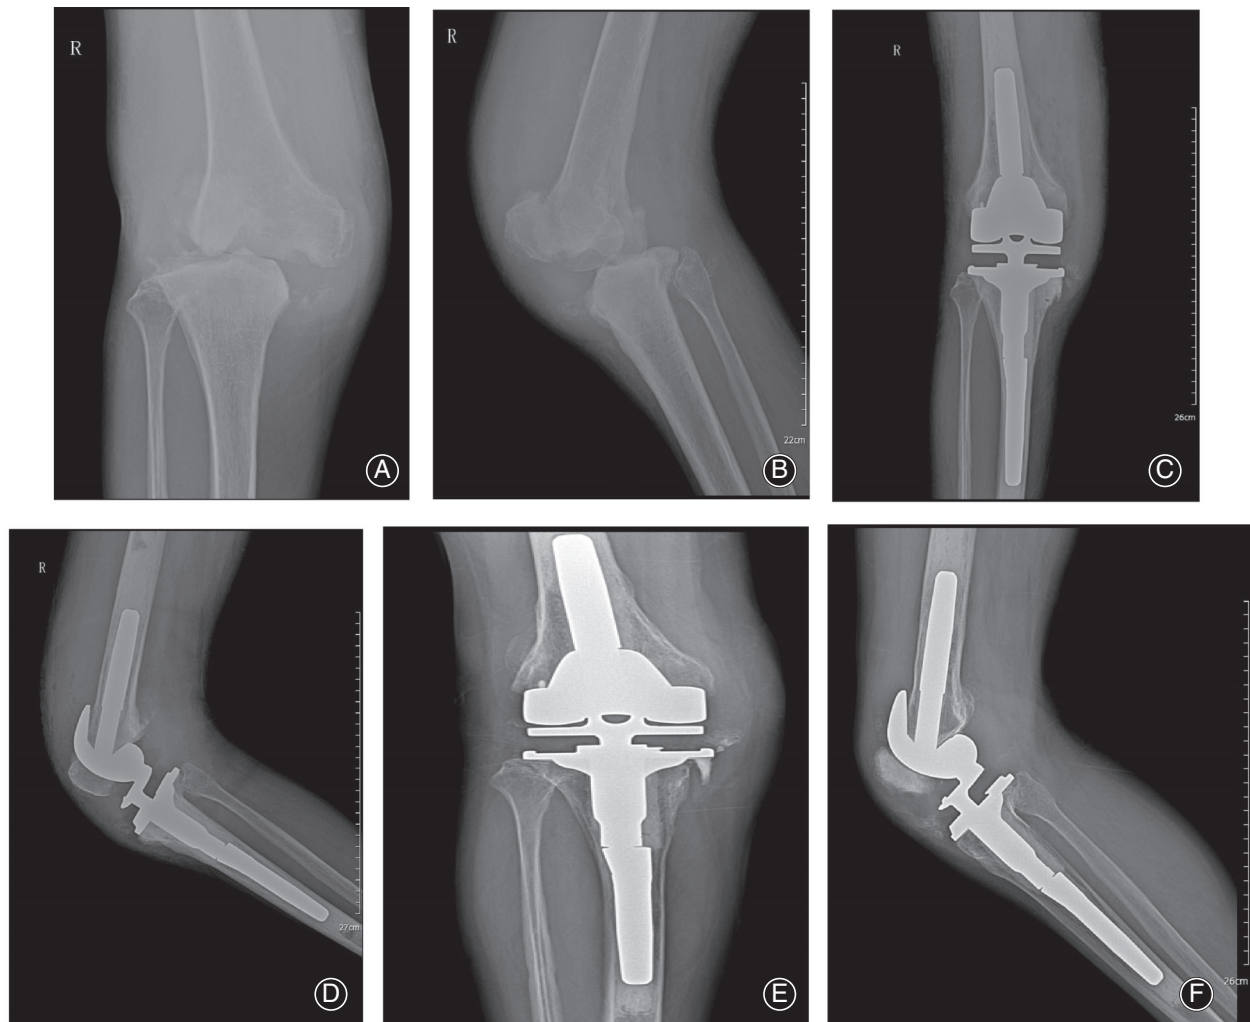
A 48-year-old female with Charcot's joint disease in her right knee. During surgery on the patient with Charcot's arthropathy, turbid synovial fluid, hypertrophy, congestion and edema, dark red and patchy exfoliation of the cartilage, exposed subchondral bone, sclerosis, and free bone fragments in the synovial tissue were observed. (A, B): Preoperative X-ray of the right knee showing a swollen joint, bony destruction, and subluxation; (C, D) X-ray showing a normal, rotating hinged prosthesis after total knee arthroplasty (TKA); (E, F) X-ray showing the stable prosthesis and the absence of soft tissue swelling, 2 years after the index TKA.
